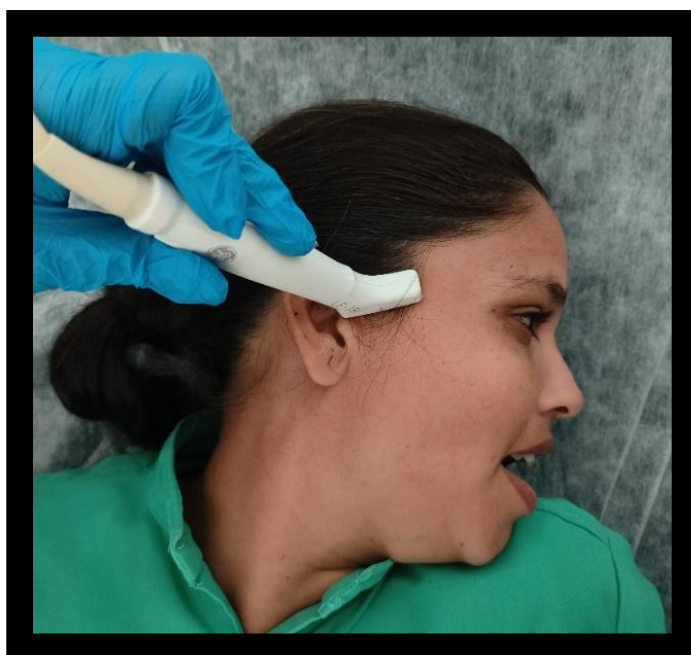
Position of probe on skin surface to locate the disc on ultrasonography (open mouth)
